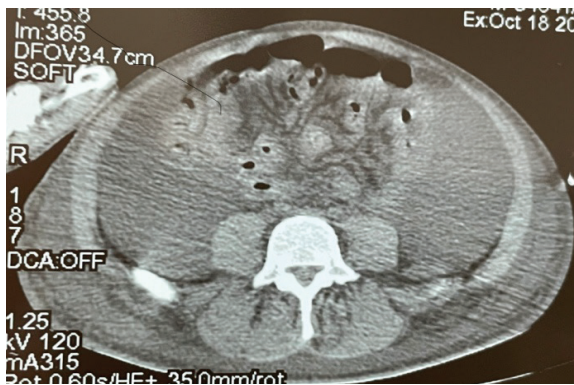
Abdomino-pelvic CT
